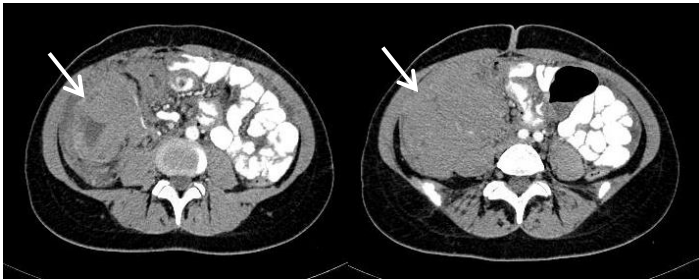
Abdominal computed tomography shows a mass (arrow)
